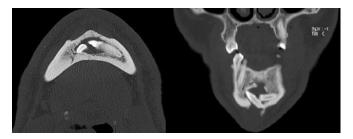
Axial section on the left side and coronal section on the right side of the CT images show impacted teeth and borders of the cyst
